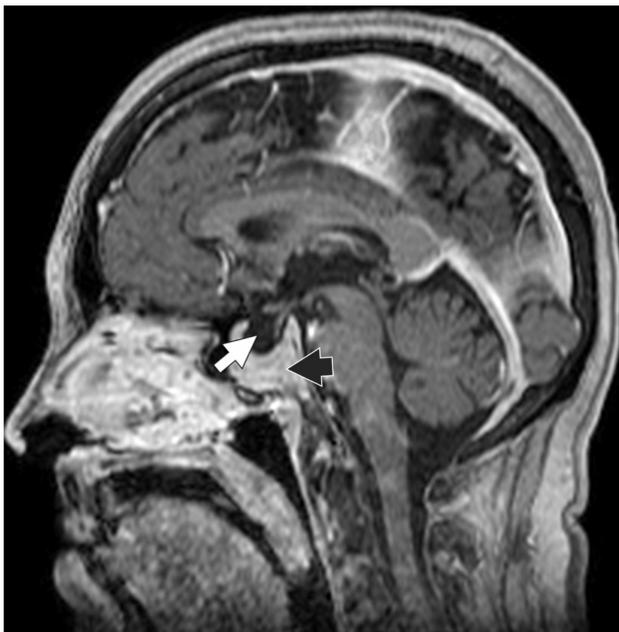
Magnetic resonance imaging of the brain, midsagittal section, T1-weighted sequence after gadolinium administration, case four. Empty saddle signal (white arrow), massive lesion occupying the sphenoid sinus (black arrow), with homogeneous postcontrast enhancement.
